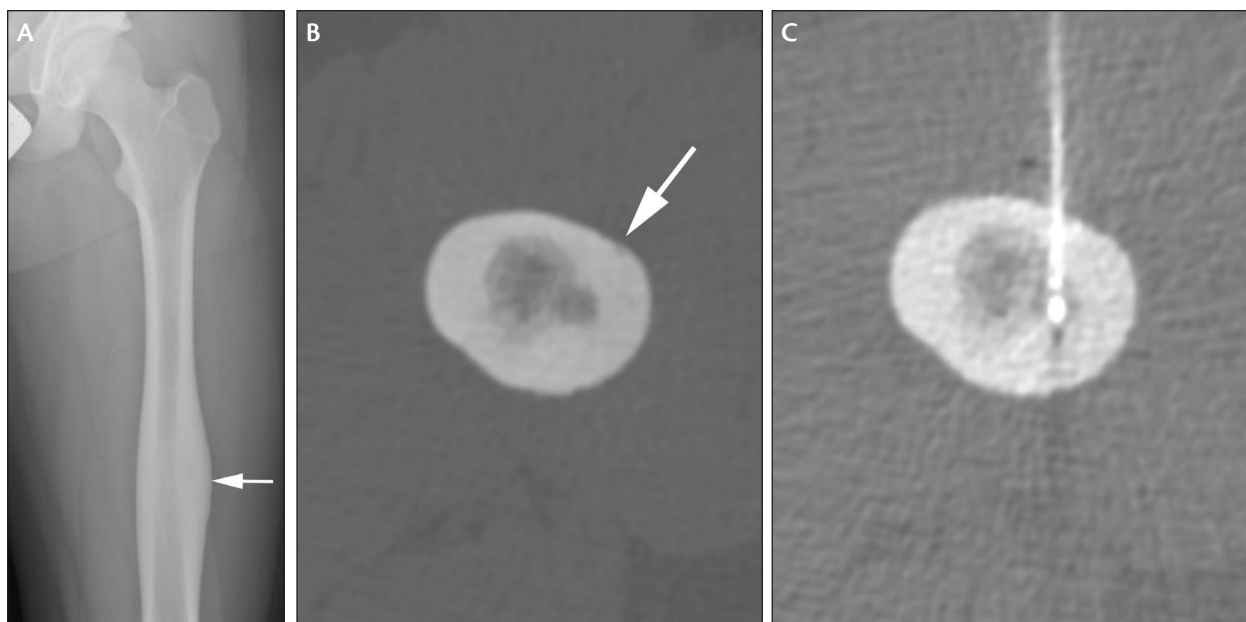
Left femur radiograph (A) and CT (B) demonstrating osteoid osteoma. Radiofrequency ablation probe placement (C) at the time of ablation.
